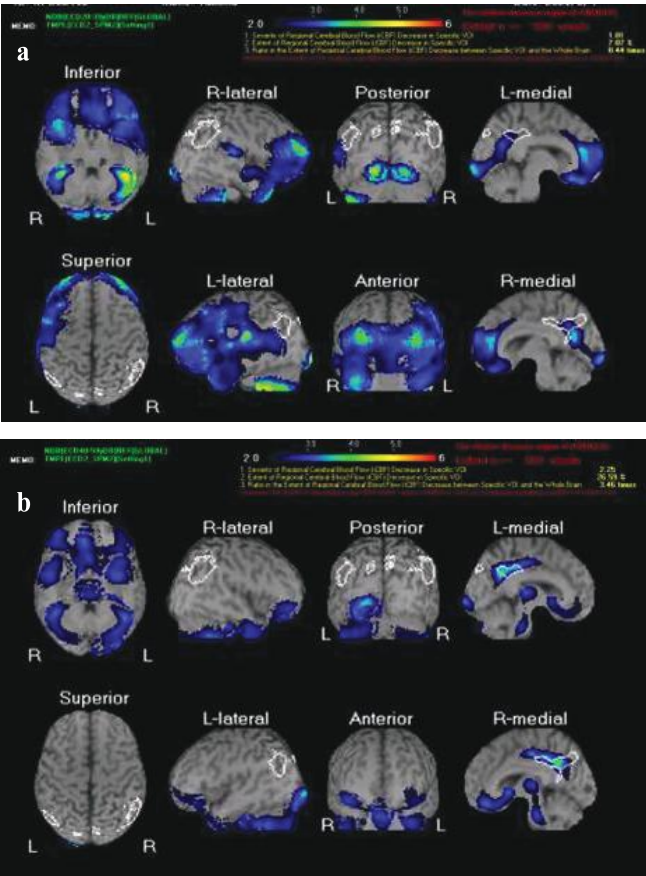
Representative 99mTc ECD Brain SPECT images showing cerebral perfusion before (a) and after (b) Vitamin D3 supplementation in a patient with neuropsychiatric lupus. Note the improvement in frontal lobe and precuneus region perfusion (indicated by arrows), corresponding with the overall reduction in hypoperfusion rates observed across study participants.
